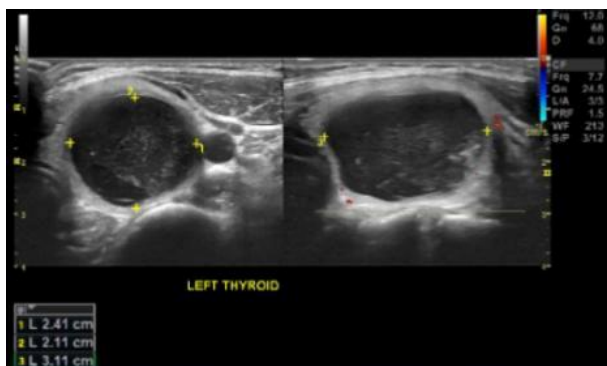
Thyroid ultrasound showed enlargement with cystic lesion of left thyroid.
